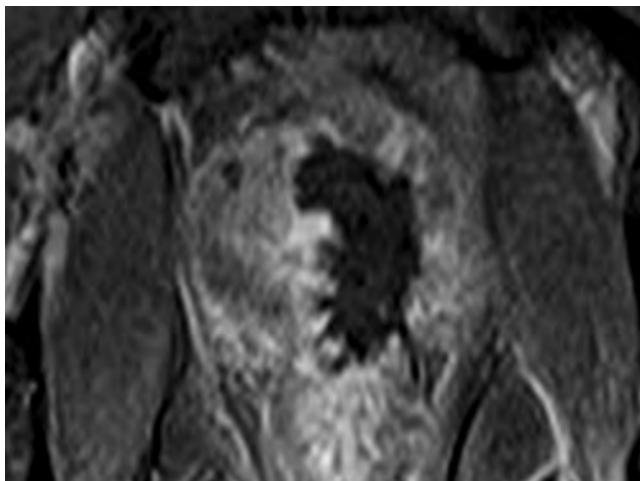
Early contrast magnetic resonance imaging after repeated focal high-intensity focused ultrasound shows excellent treatment effect. The patient was found to be cancer free on mapping template biopsies 2 years later.
